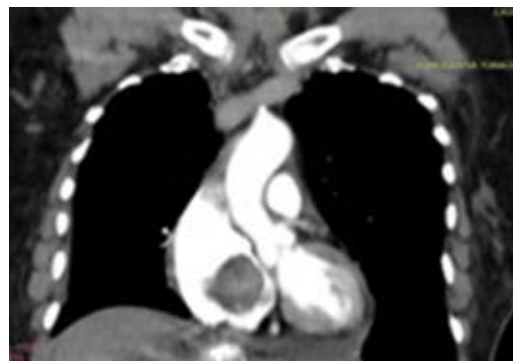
Contrast CT scan showing a mass in the RA and RV, predominantly hypodense, heterogeneous, with no significant enhancement after contrast. Seated on the interventricular septum, occupying the tricuspid entry point and partial extension to the RV outflow tract. No calcifications.
